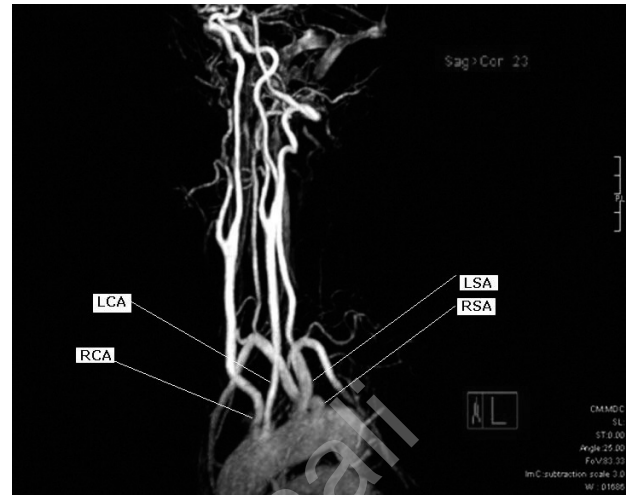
MRI angiogram. Separate origin of supraortic arteries. RCA: right carotid artery. LCA: left carotid artery. LSA: left subclavian artery. RSA: right subclavian artery.
